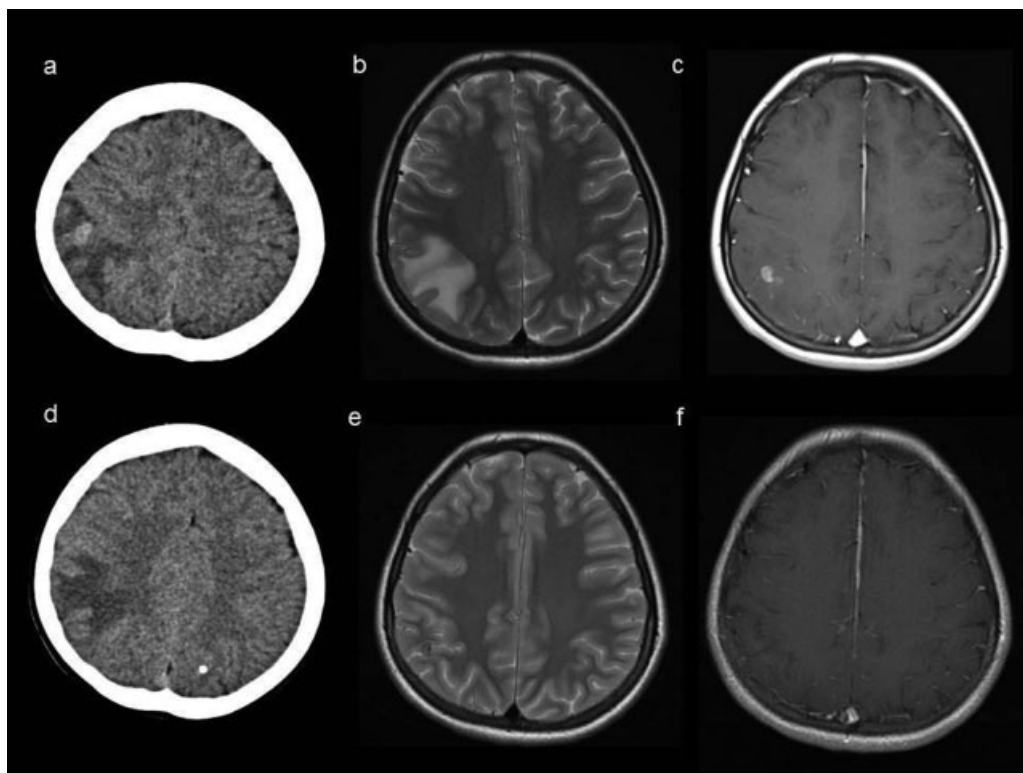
Case 1. (a) Computed tomographic (CT) scan of the brain at presentation showing a lesion in the right parietal area. (b) T2-weighted magnetic resonance imaging (MRI) scan at presentation showing edema in the right parietal lobe. (c) T1-weighted MRI scan with gadolinium at presentation showing a partially enhancing annular lesion with perilesional edema. (d) CT scan of the brain showing a calcified lesion in the left parietal lobe. (e, f) T2-weighted MRI scan and T1-weighted MRI scan with gadolinium at follow-up show reduction of the edema and the lesion in the right parietal lobe.
